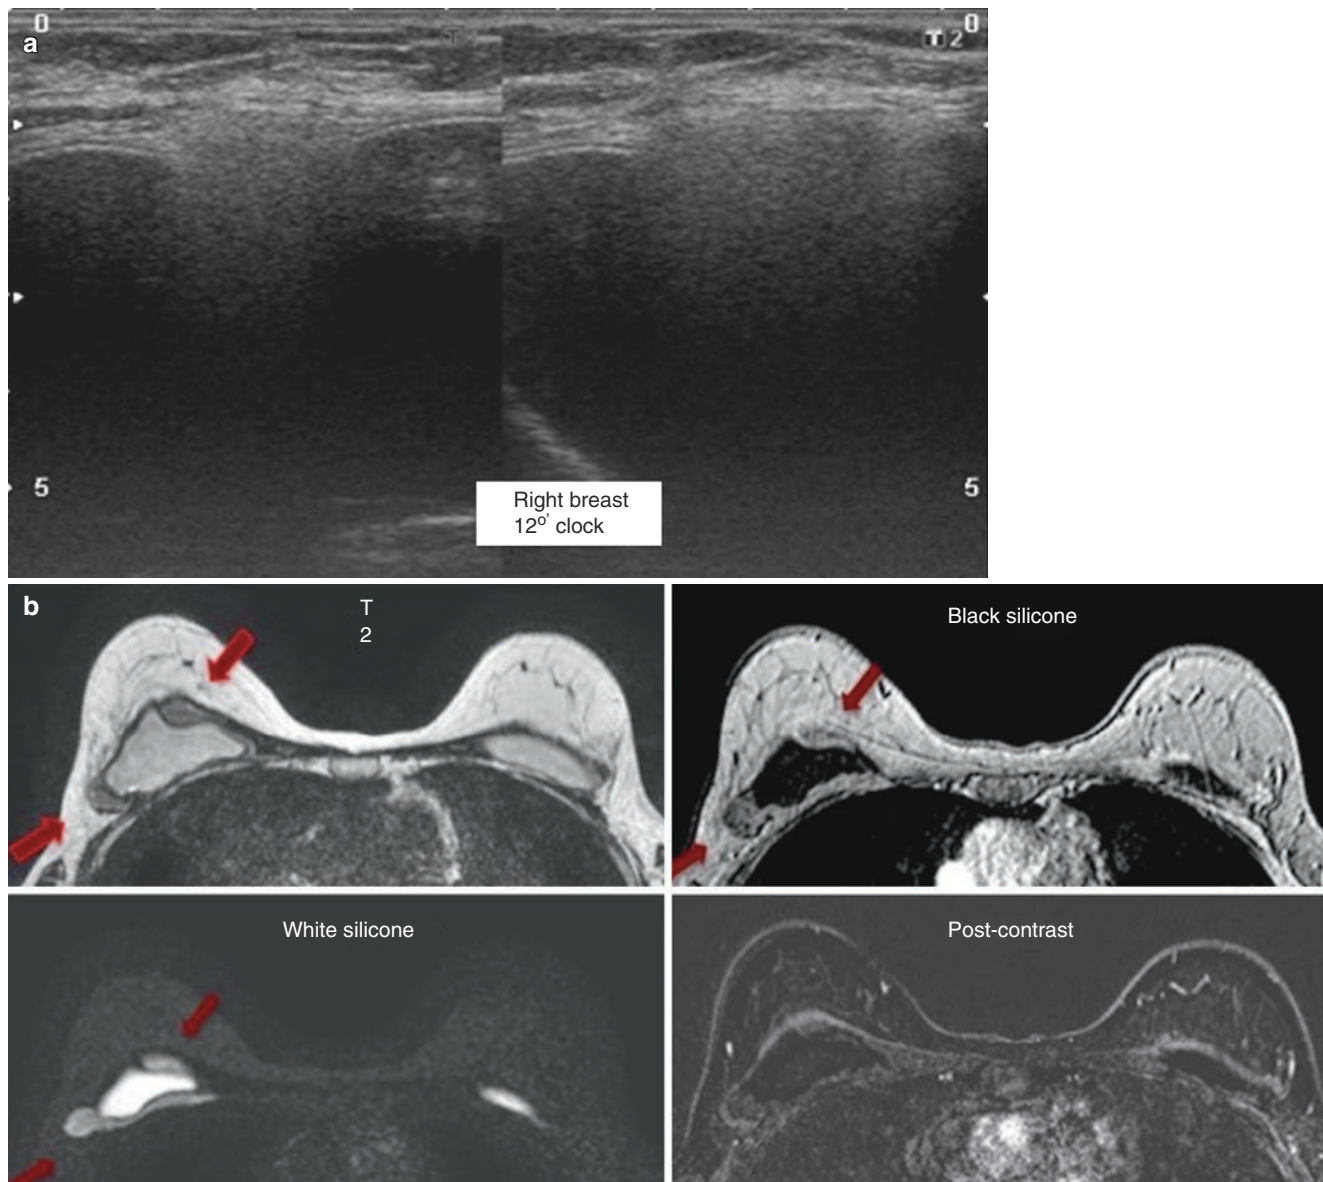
Patient with personal history of extracapsular rupture with silicone extravasation. The surgeon referred the patient for replacement and cleaning. (a) Ultrasound was performed in a screening and a snowstorm sign was around some areas of the implant that prevented assessment of the capsule, suggesting extracapsular rupture. The patient wanted a definitive diagnosis before a new replacement surgery. (b) MRI was performed. An extracapsular material around the implant was seen, with signal intensity that did not correspond to free fluid but was
